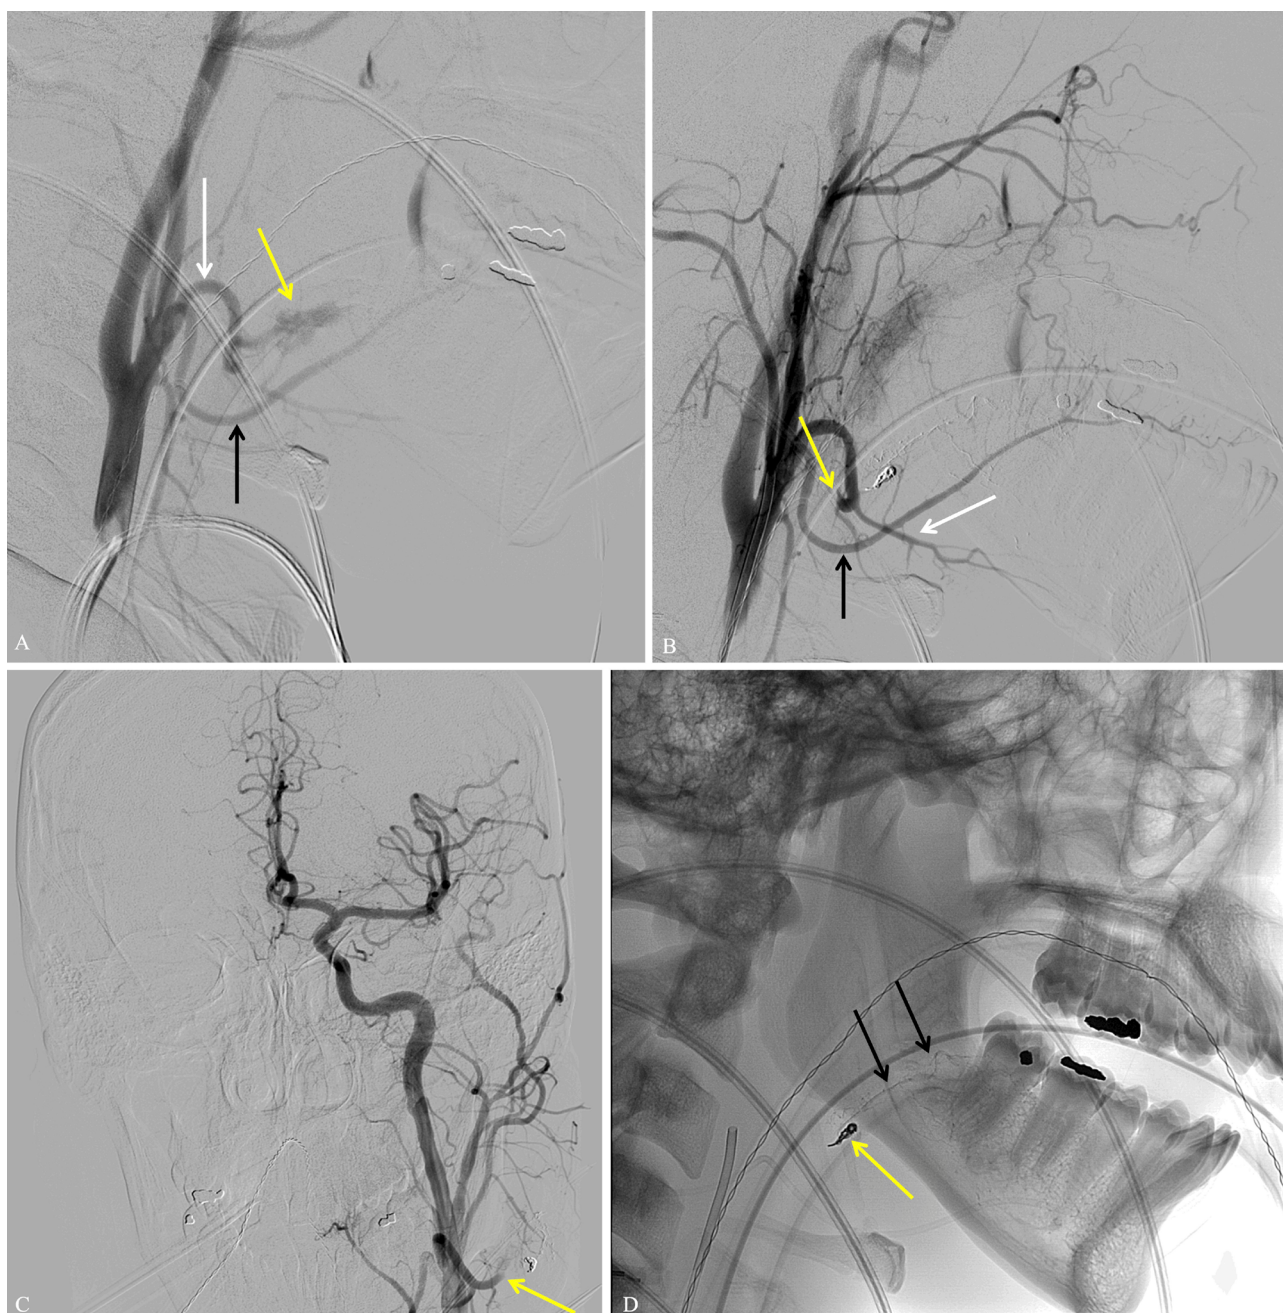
(A) Lateral digital subtraction angiogram (DSA) from the left common carotid artery demonstrating pseudoaneurysm (*yellow arrow*) coming off the 2nd order branch of the facial artery (*white arrow*). The lingual artery in inferior to the facial artery (*black arrow*). (B) Post-embolization DSA demonstrating successful cessation of flow in 2nd order facial artery and pseudoaneurysm and preservation of flow in the other 2nd order branch off facial artery, submental artery (*white arrow*). The lingual artery is inferior (*black arrow*). (C) Anterior-to-posterior DSA demonstrating normal cerebral angiogram and successful 2nd order facial artery embolization (*yellow arrow*). (D) Lateral radiograph post embolization demonstrating coil pack (*yellow arrow*) and glue in adjacent 3rd order facial artery branches (*black arrows*) in region of wisdom tooth extraction.
